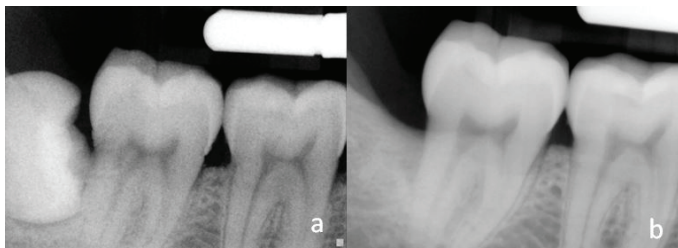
Mesioangular IMP; a) Pre-operative radiograph; b) Post operative radiograph showing angular defect distal to M2 at re-assessment period.
